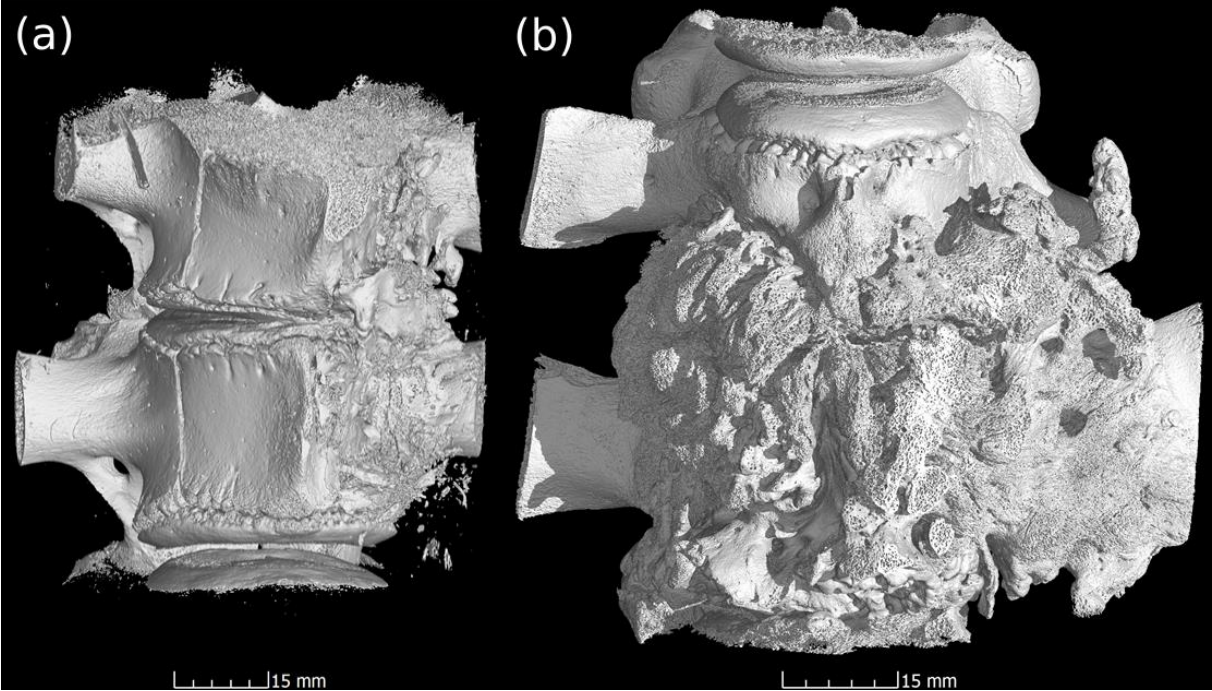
CT scan of treated site after 16 weeks after implantation, (a) novel hybrid material, (b) bone autograft, huge fibrous reaction is obvious
